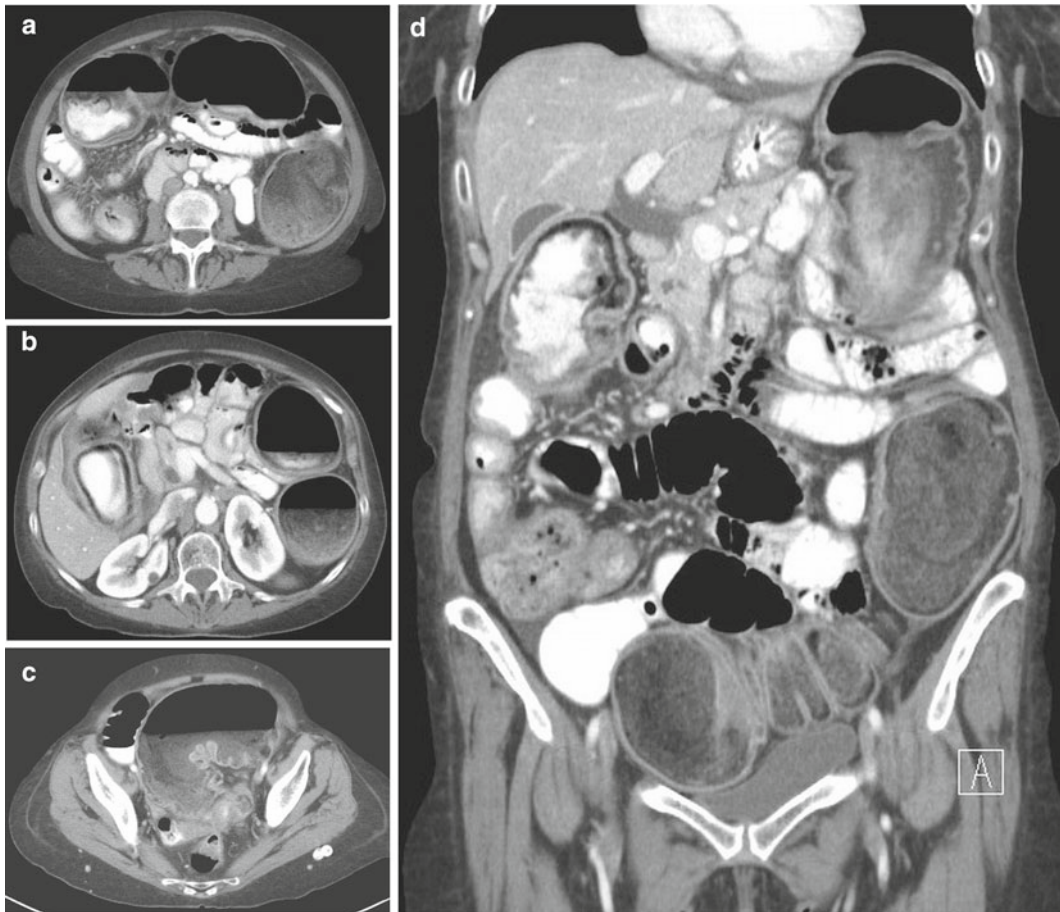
A 68-year-old woman with distended abdomen and severe constipation. (a) Axial oral and intravenous contrast enhanced CT image through the upper abdomen shows the markedly distended colon: hepatic flexure is on the *right* and splenic flexure on the *left*. (b) Axial oral and intravenous contrast enhanced CT image through the mid abdomen shows distended, fecal material filled colon. Note
